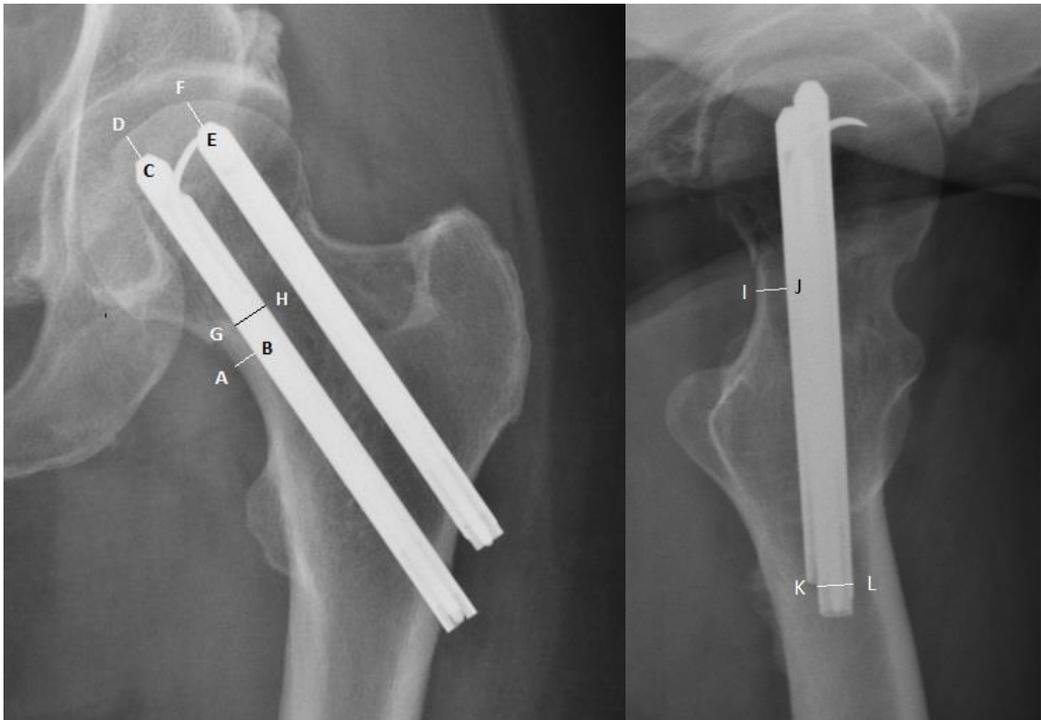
Measurements of distances in the post-surgery x-rays. AB = Calcar distance: The shortest distance from the inferior implant to the calcar, measured distally to the fracture on the post-surgery AP x-ray. CD and EF = tip-caput distance for each implant: Distance from the tip of the implants to the surface of the caput. GH and KL = size of the implant, IJ = Posterior distance: The shortest distance from the posterior implant to the posterior cortex of the femoral neck, measured distally to the fracture on the post-surgery axial x-ray. Angles MNO and MPQ = implant-shaft angle for posterior and inferior implant: Angle between lateral cortex of the femoral diaphysis and the implant, measured on the AP x-ray.
